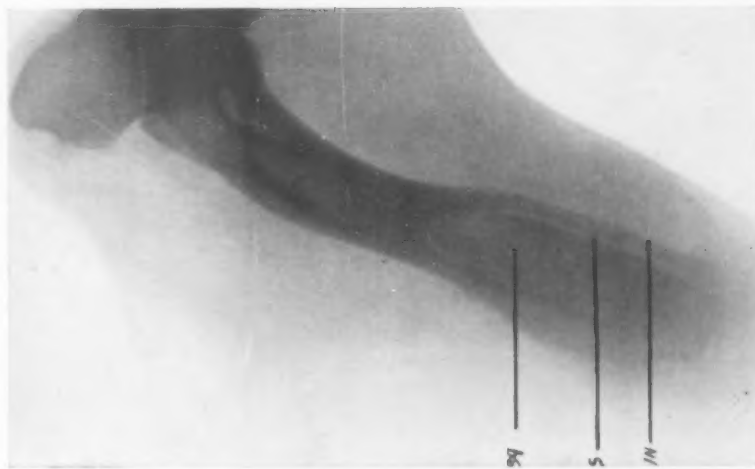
(Path. No. 6692).—Operation September 21, 1920. Procedure: Capillary tube containing croton oil inserted in medullary canal. X-ray, October 15, 1920, shows large sequestrum in upper half of humerus. Sq, sequestrum; In, involucrum; S, separate zone.
